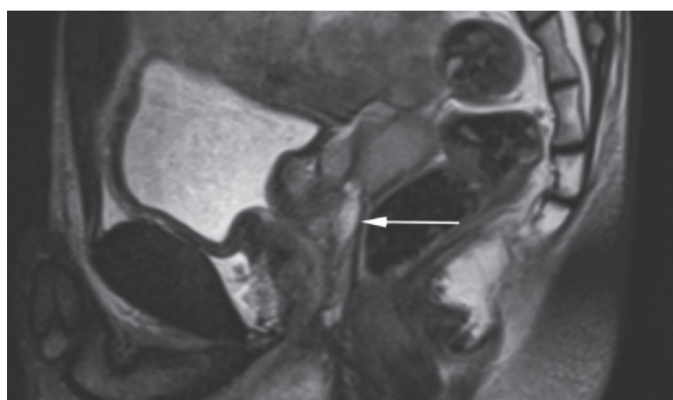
Sagittal T2 weighted image magnetic resonance imaging images shows enlargement of ejaculatory duct (arrow)
